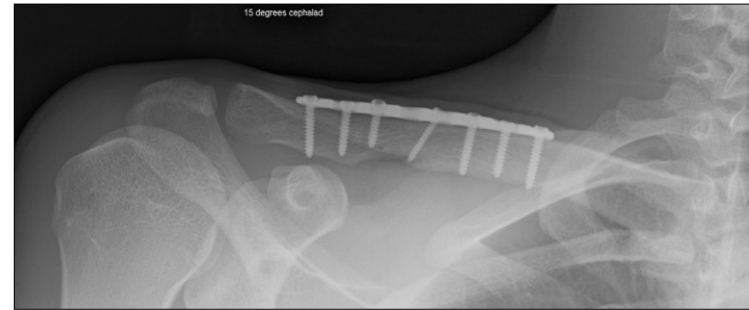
A postoperative radiograph demonstrating superior plating with three bicortical screws medially and distally and one interfragmentary screw. The patient returned to sports at 3 months postoperatively with no complaints or functional limitations.
